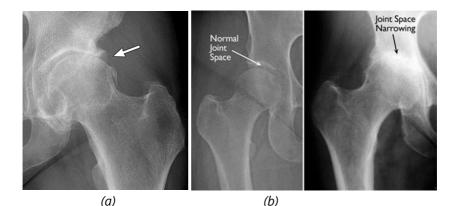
Radiographs of (a) Osteoarthritis and (b) Rheumatoid arthritis of hip joint
